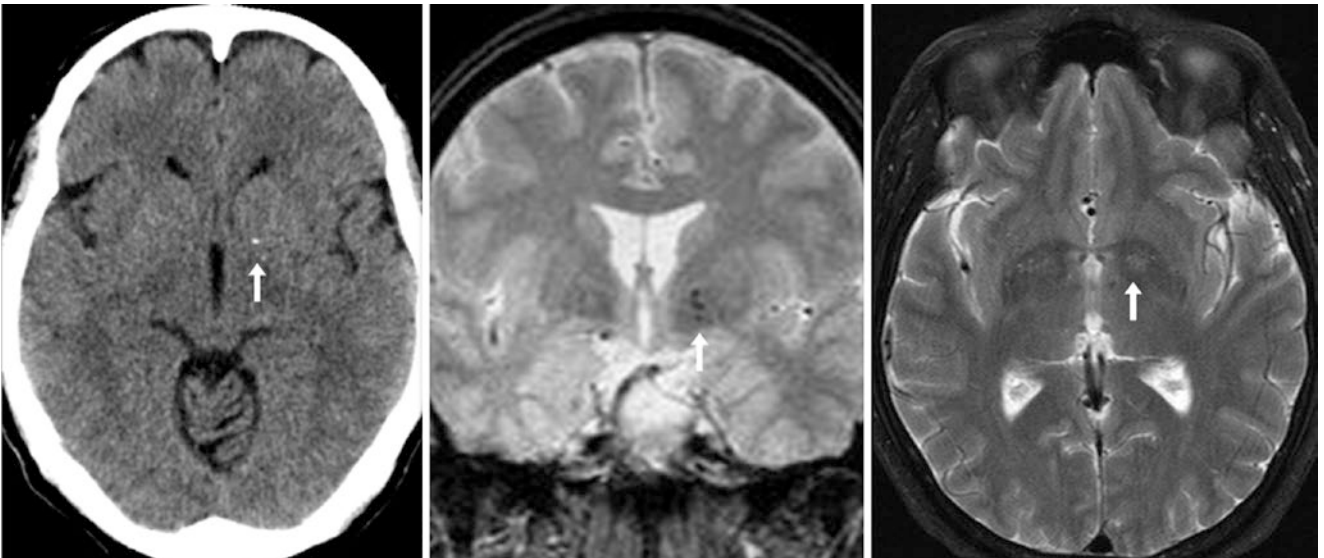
A 71 year old who had a tiny left BG calcification (*arrows*) on NECT (*left*) and on a 1.5T MRI with GE T2*WI (*middle*). On routine T2WI (*right*), the calcification is not noted, as turbo spin echo images remove much of the susceptibility effects of calcium by multiple 180° refocusing pulses (turbo factor)
